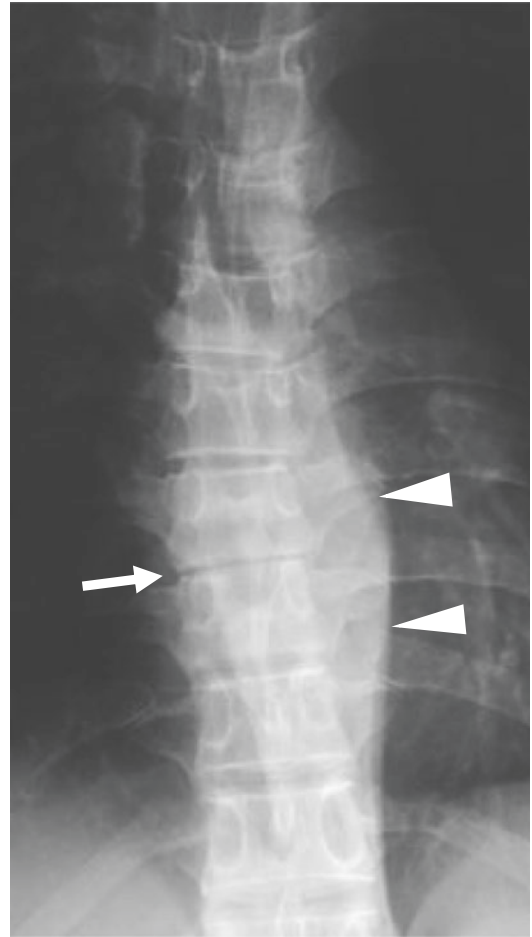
Tuberculous spondylodiscitis of the thoracic spine. Anteroposterior radiograph shows T8/T9 disc narrowing (arrow) with paravertebral soft tissue thickening (arrowheads)
